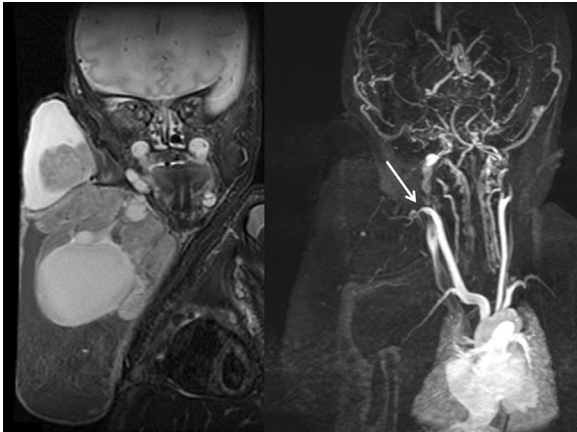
Coronal T2-weighted magnetic resonance imaging and time of flight magnetic resonance angiography maximum intensity projection of the neonatal neck. The right sided neck tumor and its supply off the right carotid artery (arrow) are demonstrated.
